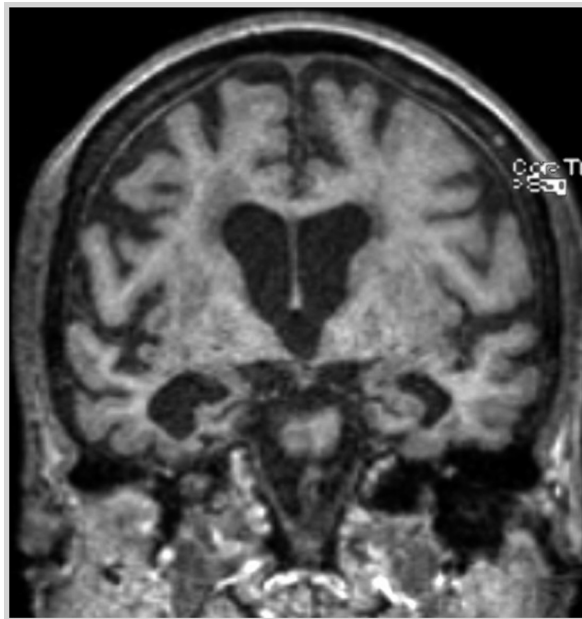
Imaging of the patient in Case 2-1. Coronal T1-weighted brain MRI showing moderate generalized cortical volume loss and regionally specific atrophy in the medial temporal lobes and hippocampal formations (right greater than left).
